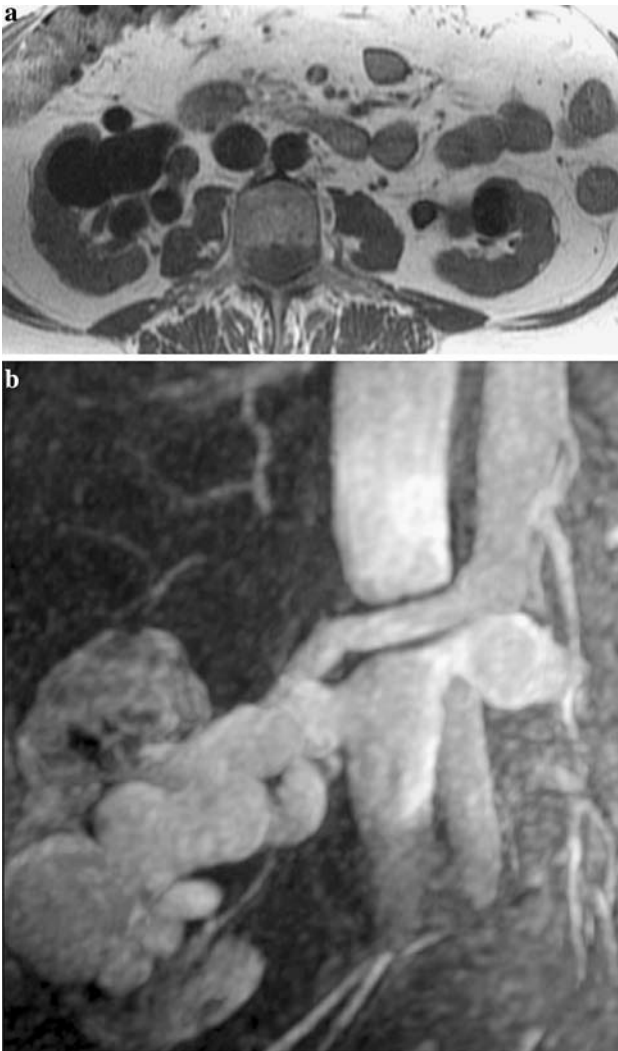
Renal arteriovenous malformation. Breath-held T1-weighted fast spin echo image (A) and venous phase reformatted image from 3D MRA (B) reveal massively dilated right renal artery and massively dilated veins, consistent with arteriovenous malformation. A left sided AV malformation was also present and is less well seen on these images.
